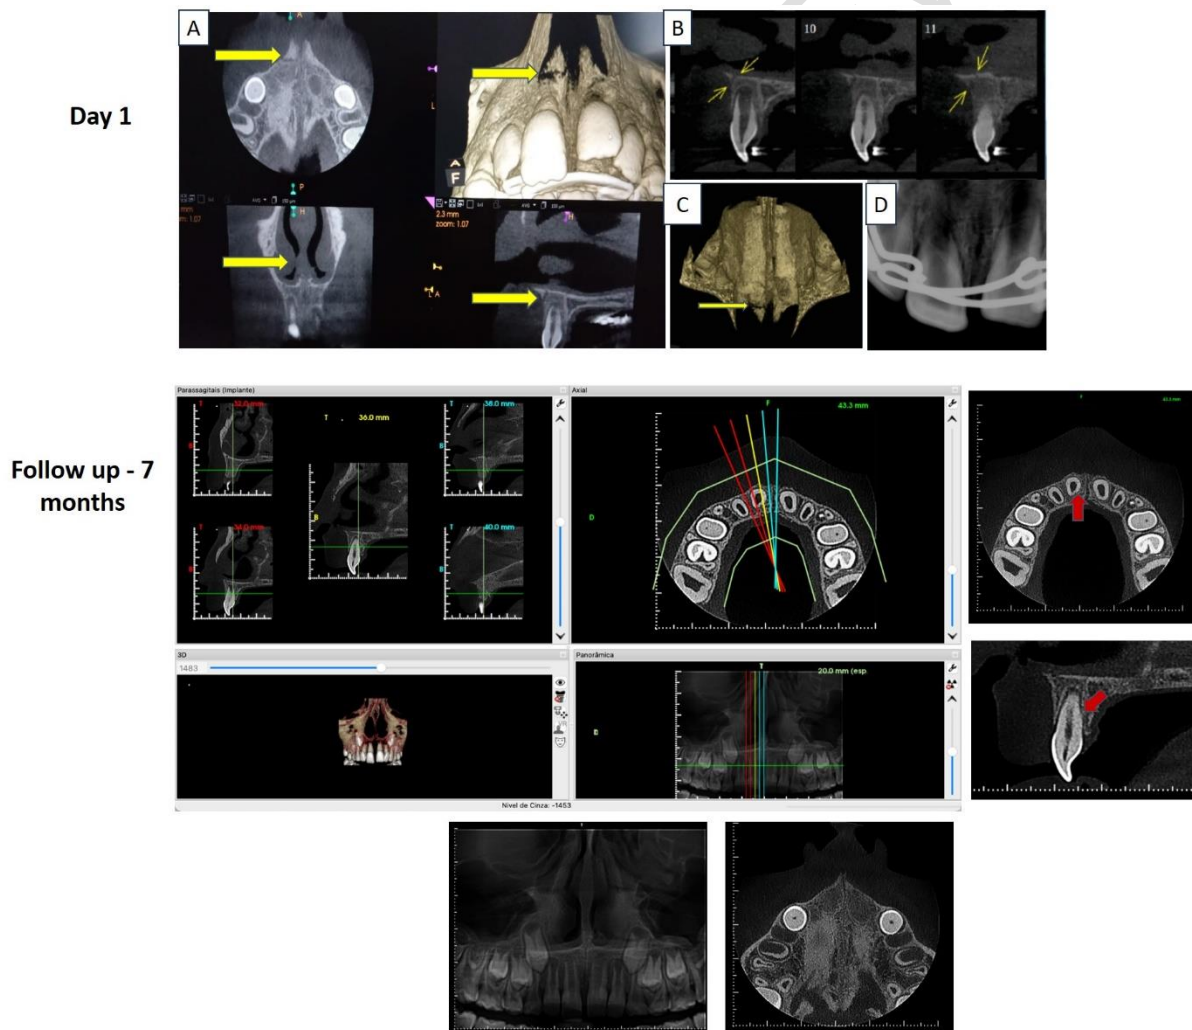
Imaging exams of the patient on the day of the trauma and after 7 months. (A, B,C): Cone Beam Computed Tomography (CBCT); D: X-ray and images of CBCT in the 7-months
